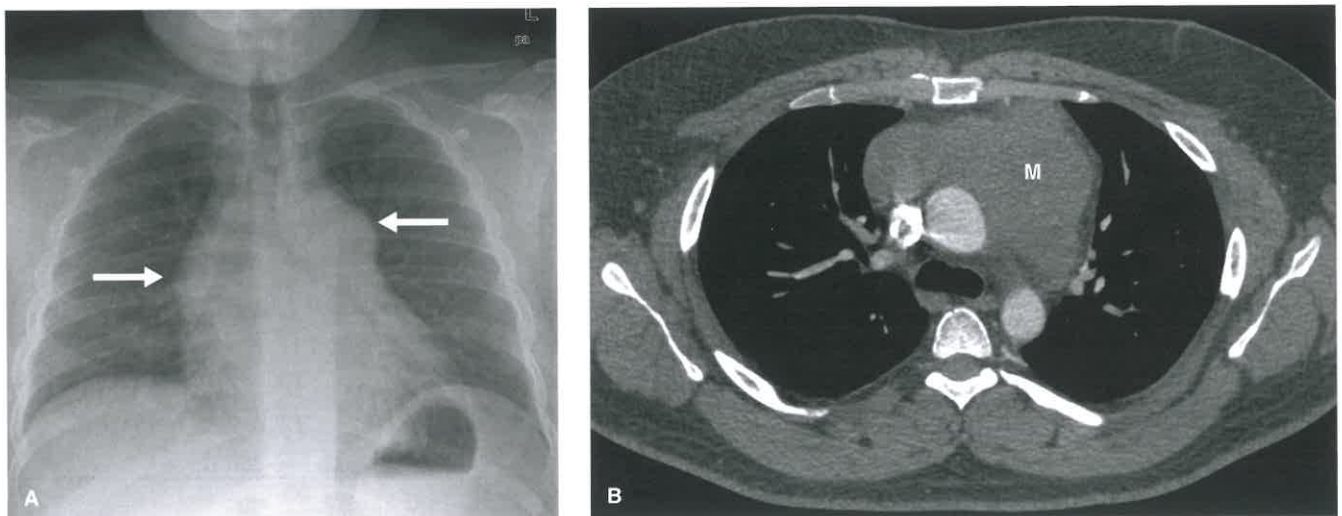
Malignant Nonseminomatous Germ Cell Tumor. A: Posteroanterior chest radiograph in a 30-year-old man reveals a mediastinal mass (*arrows*). B: Axial contrast-enhanced CT demonstrates a lobulated anterior mediastinal soft tissue mass (M). CT-guided biopsy showed a nonseminomatous tumor with mixed yolk sac and embryonal elements.
